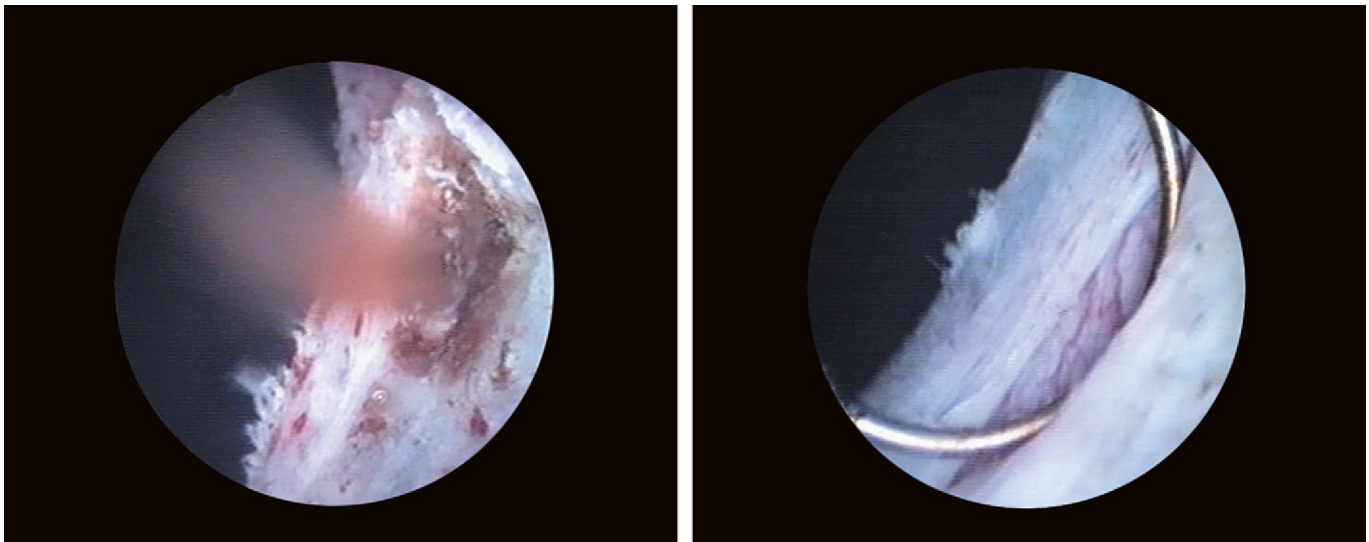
Prostatic abscess remaining after ultrasound-guided transrectal drainage.
